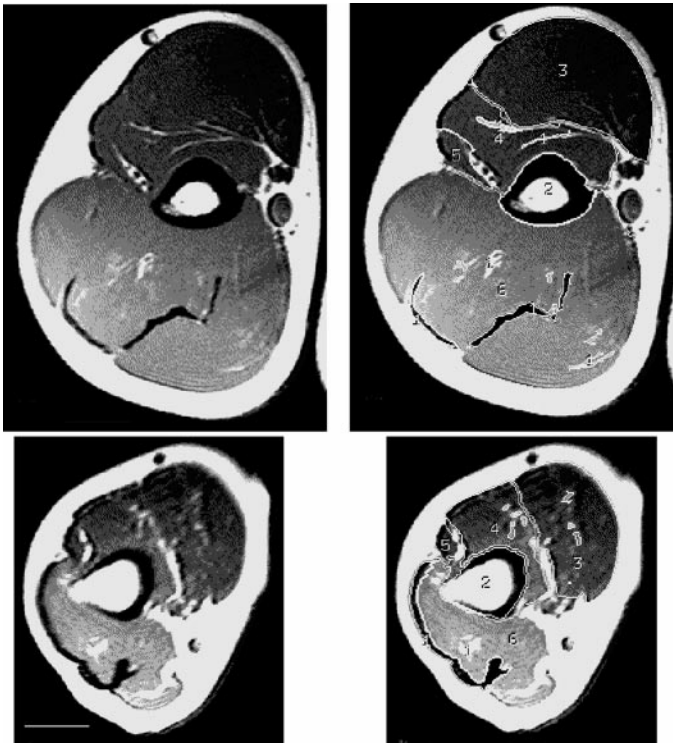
Axial magnetic resonance images of the arm from a 22-yr-old (top) and a 95-yr-old subject (bottom) showing the range of muscle size in the study. Image at left is the untraced version, and image at right is the traced (analyzed) version. The cross-sectional area of the traced region was determined for noncontractile tissue (1), humerus (2), biceps brachii (3), brachialis (4), brachioradialis (5), and triceps brachii (6). The images are 2 cm distal to the origin of the brachioradialis and are to the same scale. The horizontal bar corresponds to 2 cm.
